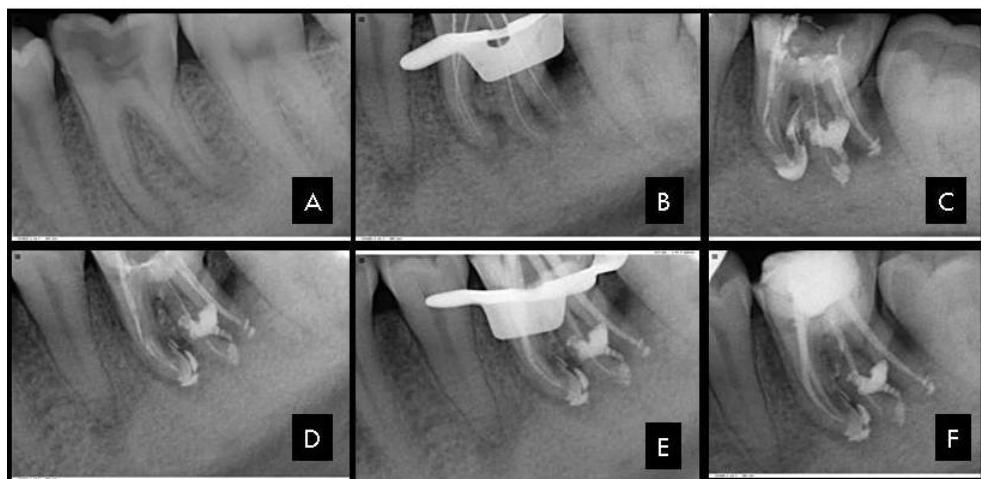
A- Pre-Operative Radiograph; B- Working Length; C- Placement of intracanal Medicament; D- After 1 month follow up; E- Master cone selection; F- Obturation followed by post endodontic treatment.
